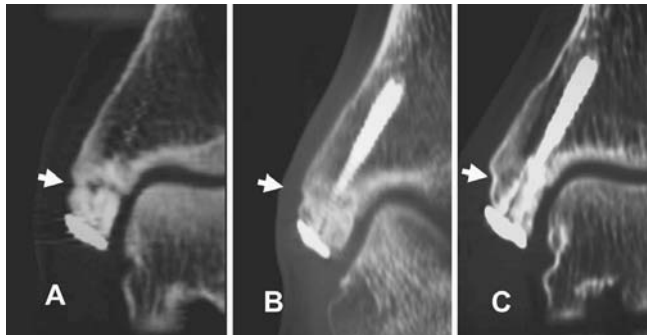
Case 5 (17-year-old male baseball player). The CT image of case 5. A, nonunion before extracorporeal shock wave therapy (ESWT); B, at 3 months after ESWT, bony union already achieved; C, at 6 months after ESWT, fusion became more complete.
